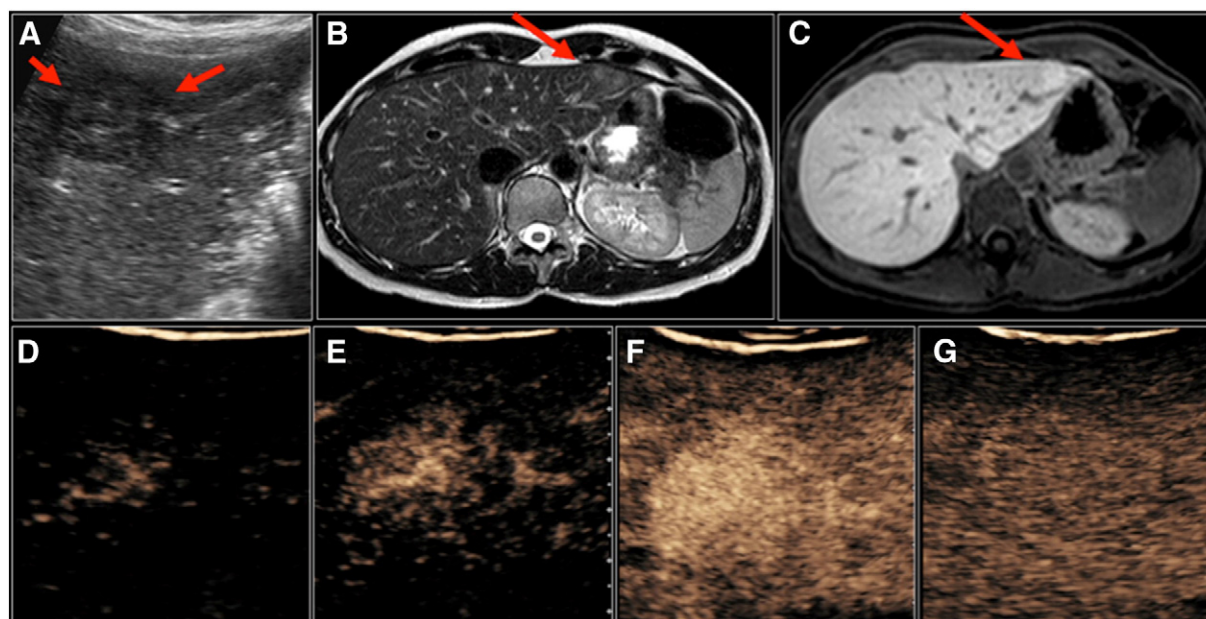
Examples for the use of CEUS in clinical liver imaging in comparison with MRI. A + B: In B-mode US and in T₂-weighted MRI, a benign liver tumor (fibronodular hyperplasia, FNH) can be delineated. C: Twenty minutes after the administration of the hepatocyte-specific MR contrast agent Gd-EOB-DTPA, the lesion and the surrounding tissue provide comparable contrast enhancement, which is typical for a FNH. D–F: In contrast-specific US mode, one can depict the rapid centrifugal (“spoke-wheel”) enhancement of the lesions. In the late phase (G; i.e. 180 s after injection), the lesion provides no wash-out pattern. Knowledge on the microbubble (MB) kinetics in the late phase enables the exclusion a malignant tumor. The enhancement pattern in the arterial phase further supports the diagnosis of a FNH.
